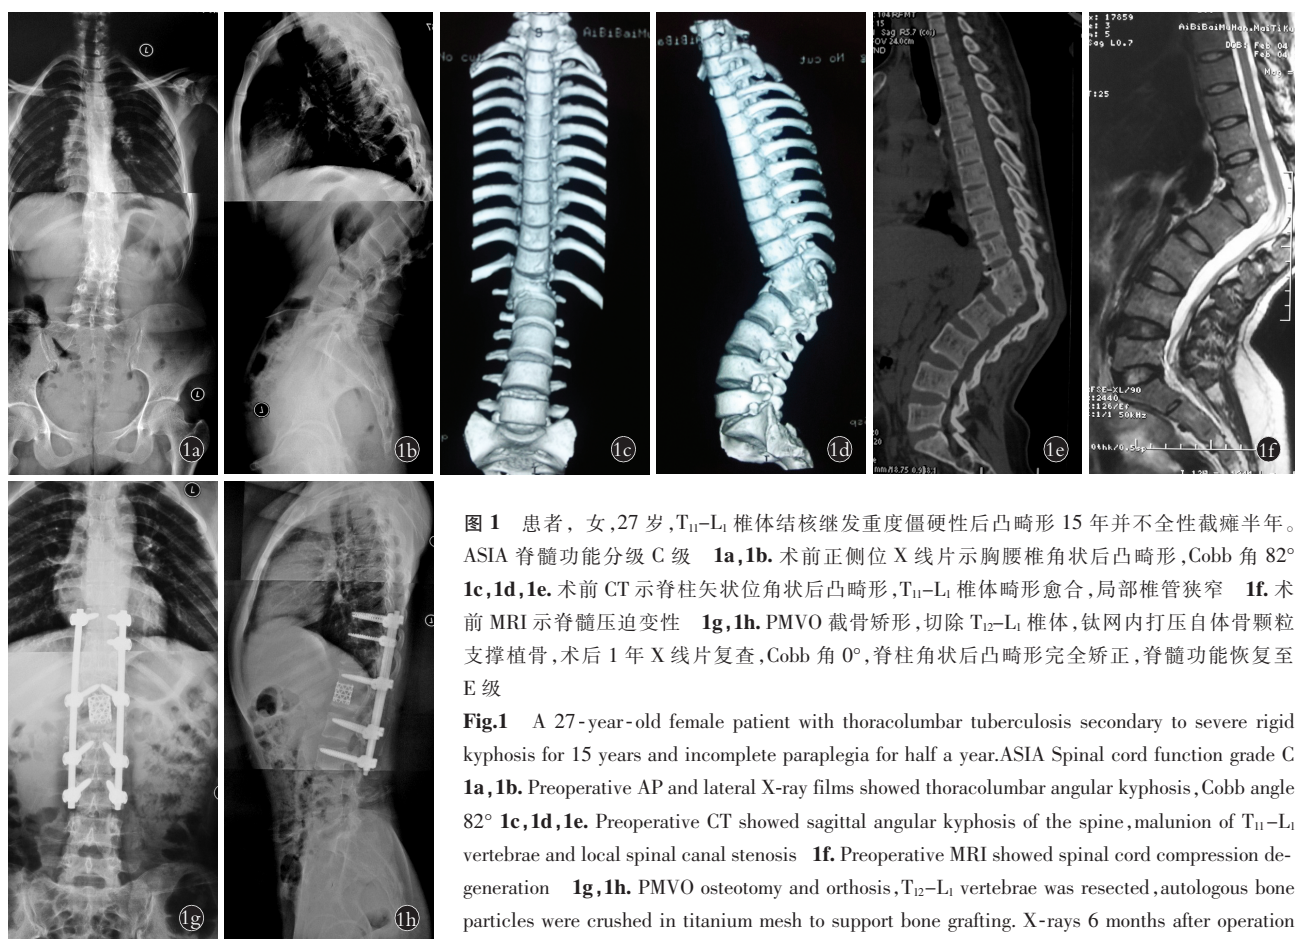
患者,女,27岁,T<sub>11</sub>-L<sub>1</sub>椎体结核继发重度僵硬性后凸畸形 15 年并不全性截瘫半年。ASIA 脊髓功能分级 C 级 1a,1b. 术前正侧位 X 线片示胸腰椎角状后凸畸形,Cobb 角 82° 1c,1d,1e. 术前 CT 示脊柱矢状位角状后凸畸形,T<sub>11</sub>-L<sub>1</sub>椎体畸形愈合,局部椎管狭窄 1f. 术前 MRI 示脊髓压迫变性 1g,1h. PMVO 截骨矫形,切除 T<sub>12</sub>-L<sub>1</sub>椎体,钛网内打压自体骨颗粒支撑植骨,术后 1 年 X 线片复查,Cobb 角 0°,脊柱角状后凸畸形完全矫正,脊髓功能恢复至 E 级
